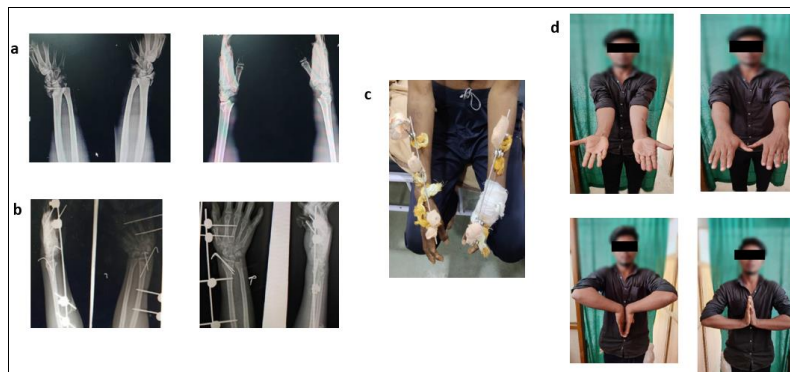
Case 3 & 4: a. Pre-operative X-Rays. b. Post-operative X-Rays. c. Post-operative clinical photo. d. Supination, Dorsi Flexion and Grip Strength (Up, left to right), Pronation, Palmer Flexion and Grip Strength (Down, left to right)
